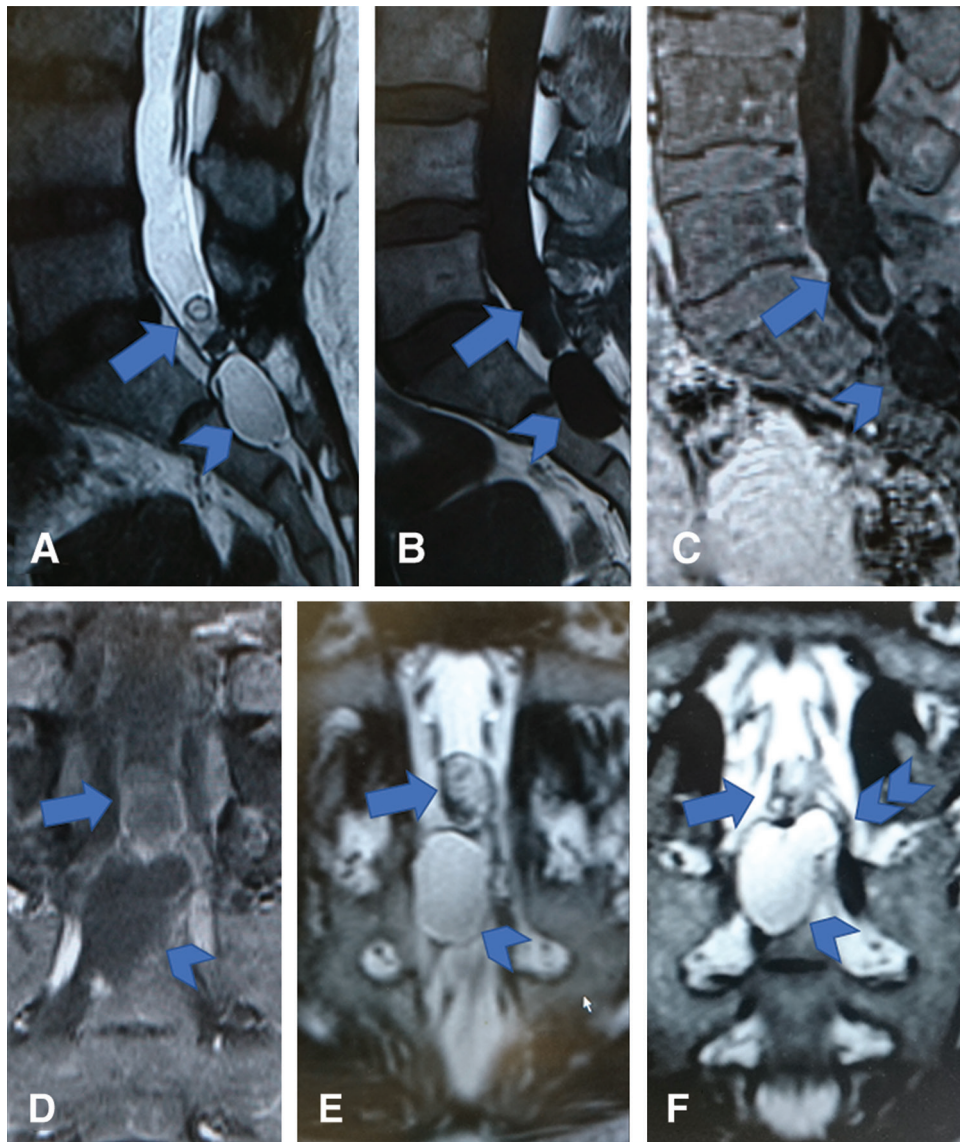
MRI of lumbosacral spine: (A) sagittal view of T2WI, (B) sagittal view of T1WI, (C) sagittal view of gadolinium-enhanced T1WI, (D) coronal view of gadolinium-enhanced T1WI, (E and F) coronal view of T2WI. MRI demonstrates a small intradural extramedullary solid lesion (arrow, 28 mm × 17 mm × 17 mm) at L5/S1 level and cystic lesion (arrowhead, 21 mm × 11 mm × 13 mm) at S2 level. MRI with contrast material revealed rim enhancement of the solid lesion (arrow, B, C, D) without any enhancement of the cystic lesion (arrowhead, B, C, D). MRI: magnetic resonance imaging, T1WI: T1-weighted image, T2WI: T2-weighted image.
